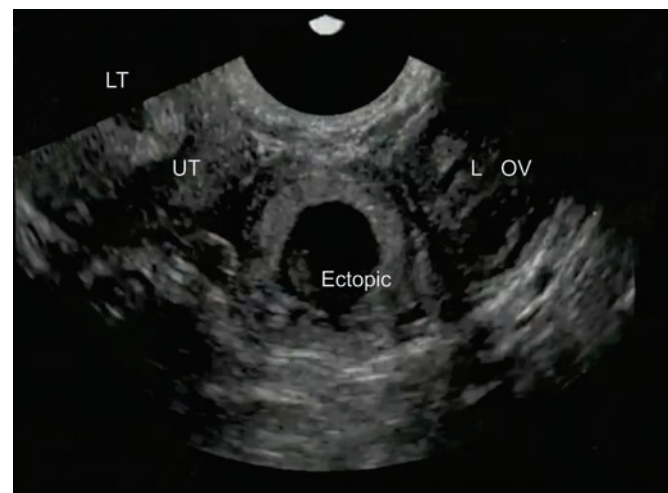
Ultrasound (LT, left tube; L OV, left ovary; UT, uterus)
